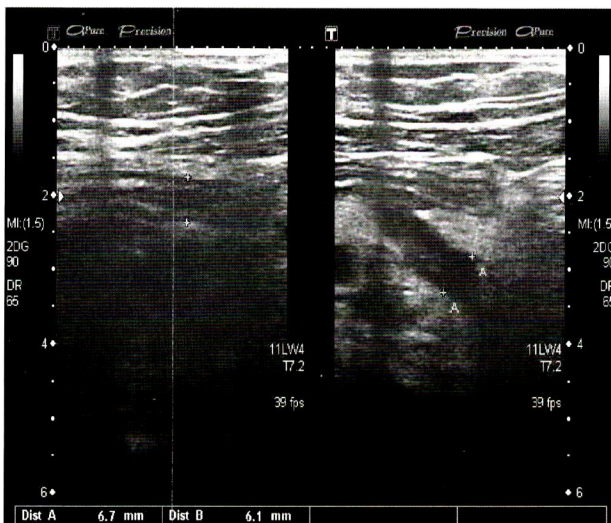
Focused ultrasound showed normal proximal appendix. The distal appendix revealed irregular thickening and hypoechoic wall with periappendiceal fat inflammation.
